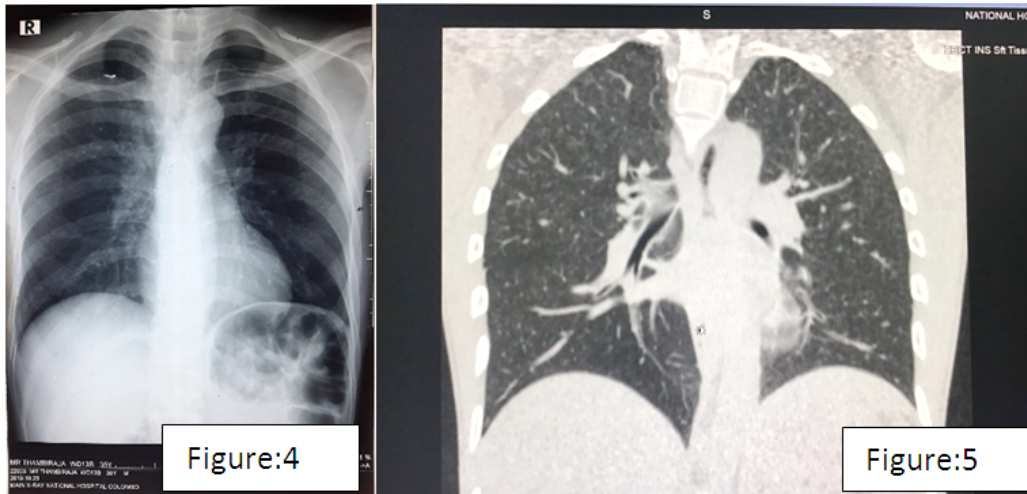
Normal chest x-ray and HRCT of first patient.
